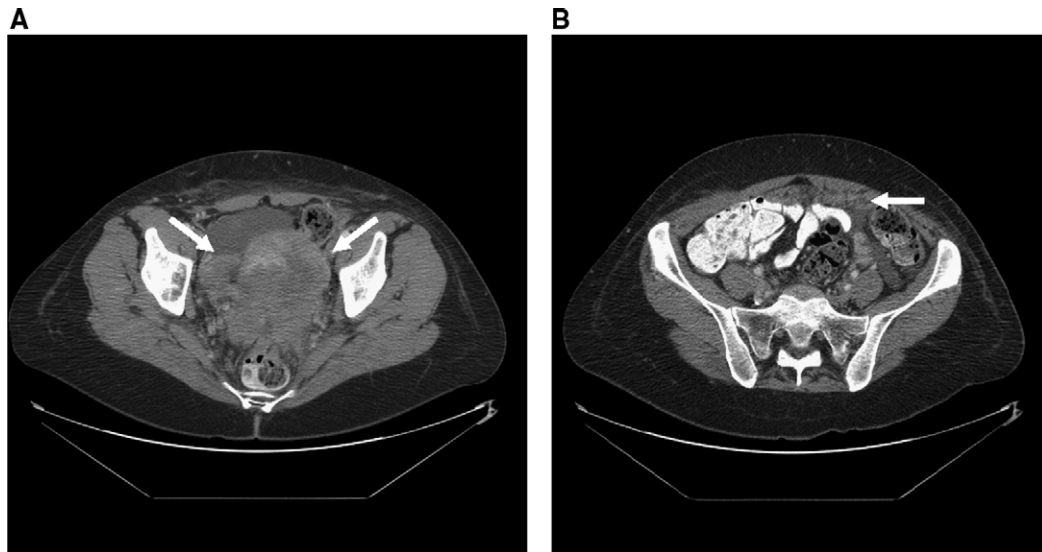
The initial computed tomographic scan obtained before treatment revealed a heterogeneous pelvic mass involving the uterus and left adnexa (A) and omental caking (B).
